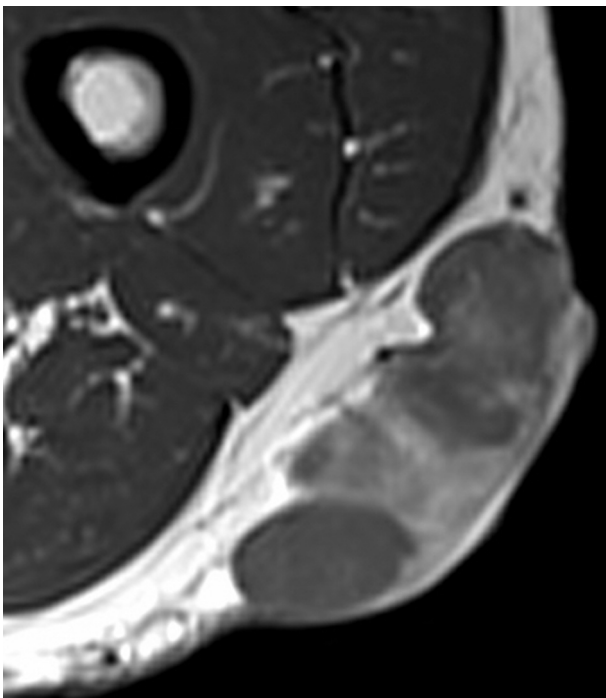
Axial T1-weighted contrast-enhanced magnetic resonance image demonstrates prominent, patchy-enhancing subcutaneous mass.
